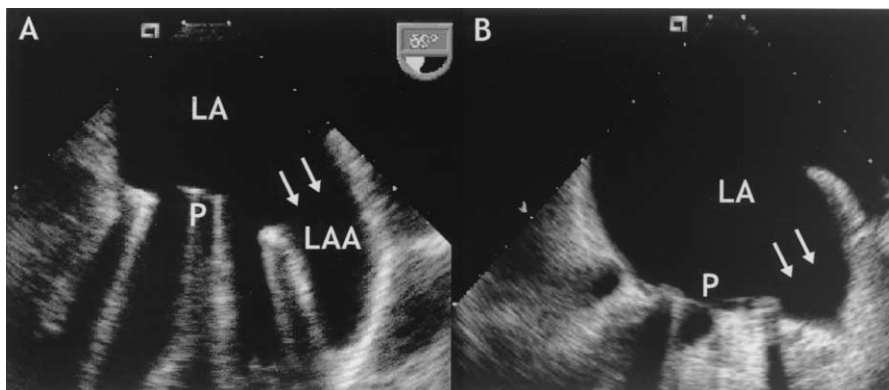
(A) Transesophageal echocardiogram in a patient with Saint Jude medical prosthesis in mitral position and without ligation of the left atrial appendage (LAA) (arrows). (B) Postoperative transesophageal echocardiographic study showing the absence of the LAA with complete obliteration of the cavity (arrows). LA = left atrium; P = prosthesis.
